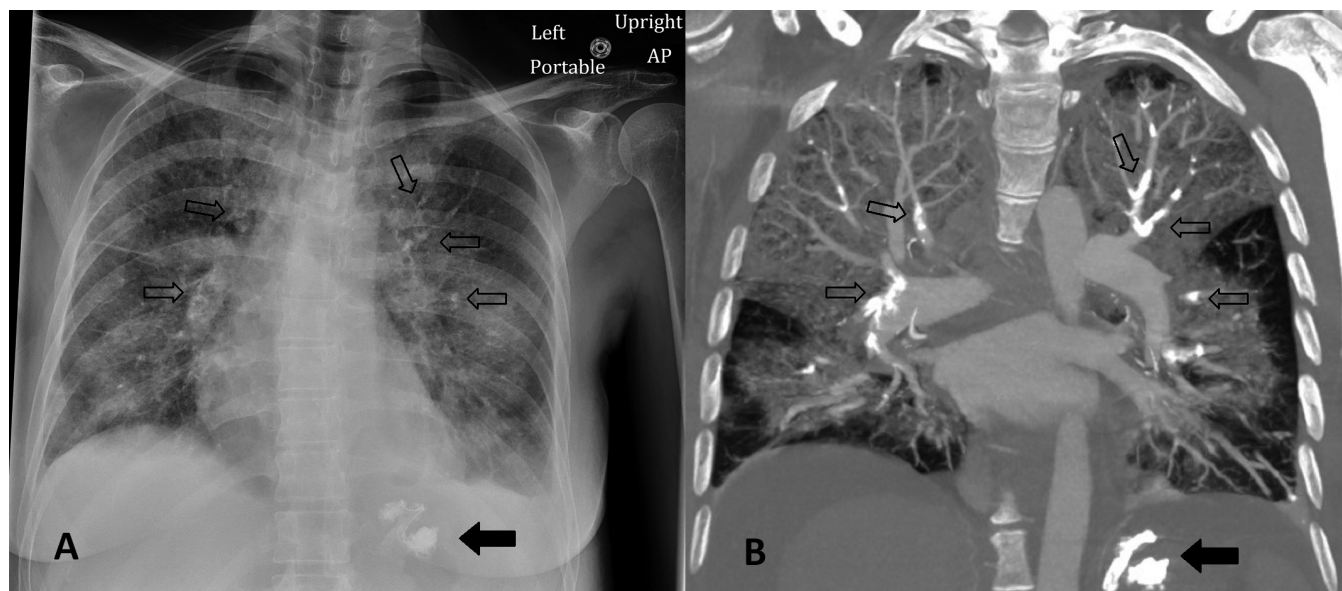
Chest imaging of a 51-year-old woman with bilateral nonthrombotic pulmonary embolism, performed 4 days after variceal obliteration. A) A chest radiograph shows increased interstitial markings and parenchymal opacities. B) A coronal slice from a chest computed tomography (CT) pulmonary angiogram shows multiple high-attenuation filling defects of the pulmonary arteries, compatible with nonthrombotic emboli of iodinated glue (hollow arrows, also seen on radiograph). High-attenuation material in the left upper abdomen shows the iodinated glue and coil embolization of a gastric varix (solid arrows). Extensive ground glass attenuation on the CT is compatible with lipiodol-related pneumonitis.
